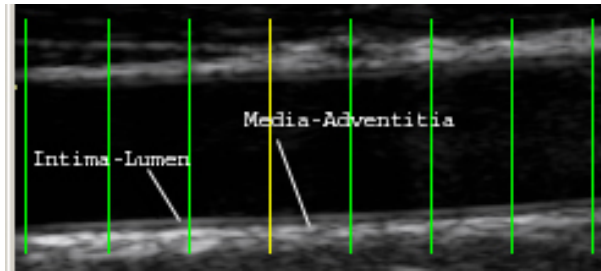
Scanning the Carotid using a linear probe (left) and the resulting ultrasound picture (right). The figure is taken from [2].
